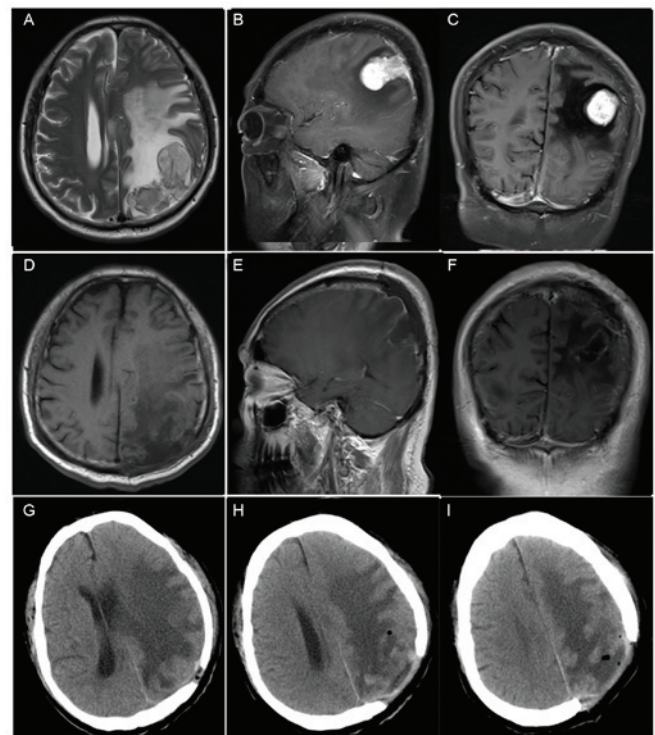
Case 4. (A) Magnetic resonance imaging of the brain shows hyperintense tumor on T2-weighted images. (B and C) Contrast-enhanced sagittal images and coronal images show a hyperintense tumor with marked enhancement in the left parietal. Peritumoral edema was evident. (D-F) Postoperative, contrast-enhanced axial, image and coronal images show that the lesion was totally resected. (G-I) A postoperative computed tomography image shows the left parietal bone defect. Case 4 was selected as complete patient data could be obtained.
